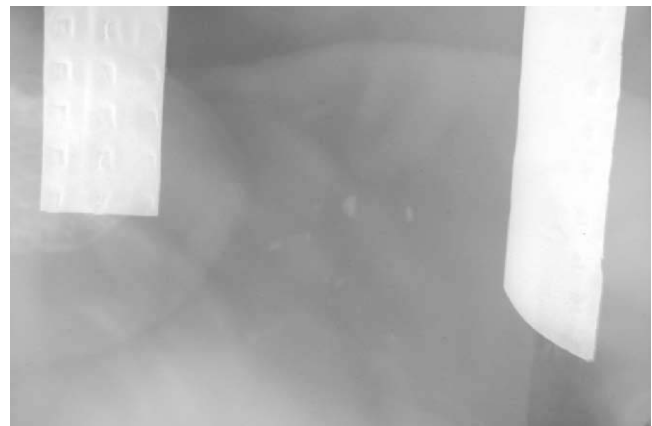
Radiograph showing several tooth fragments embedded in the lip. The reference points help the clinician approximate the location of these fragments.
